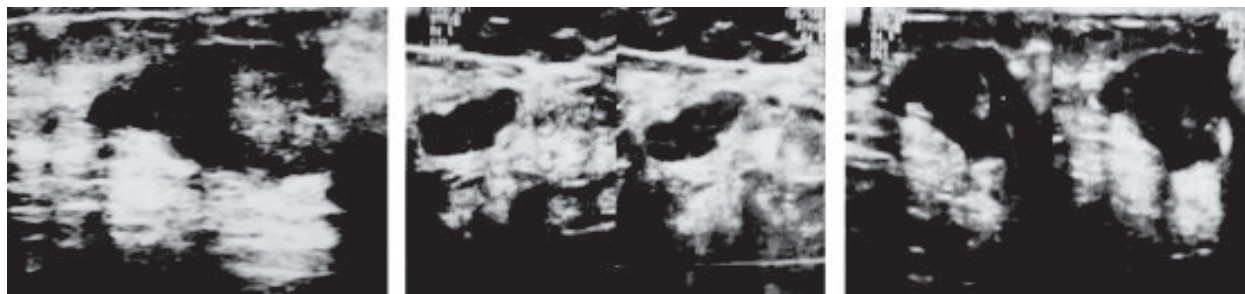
Ultrasonogram of both breasts on 23rd March 2021
